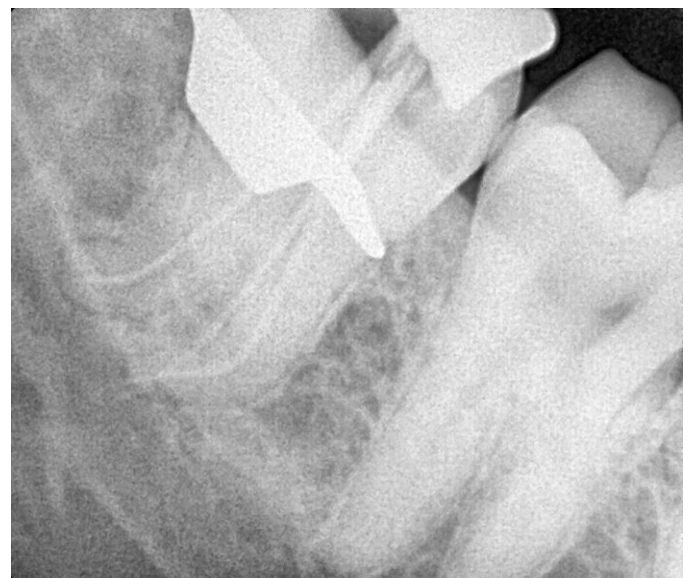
C: Master Cone Selection Radiograph
